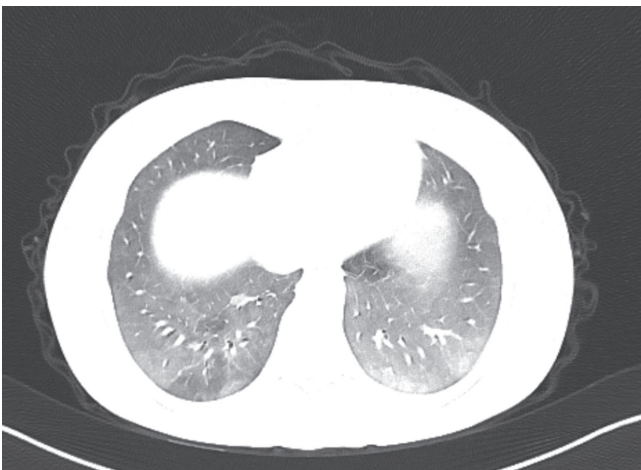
Computed tomography showed bilateral basal patchy and nodular consolidations with diffuse ground-glass opacities.
